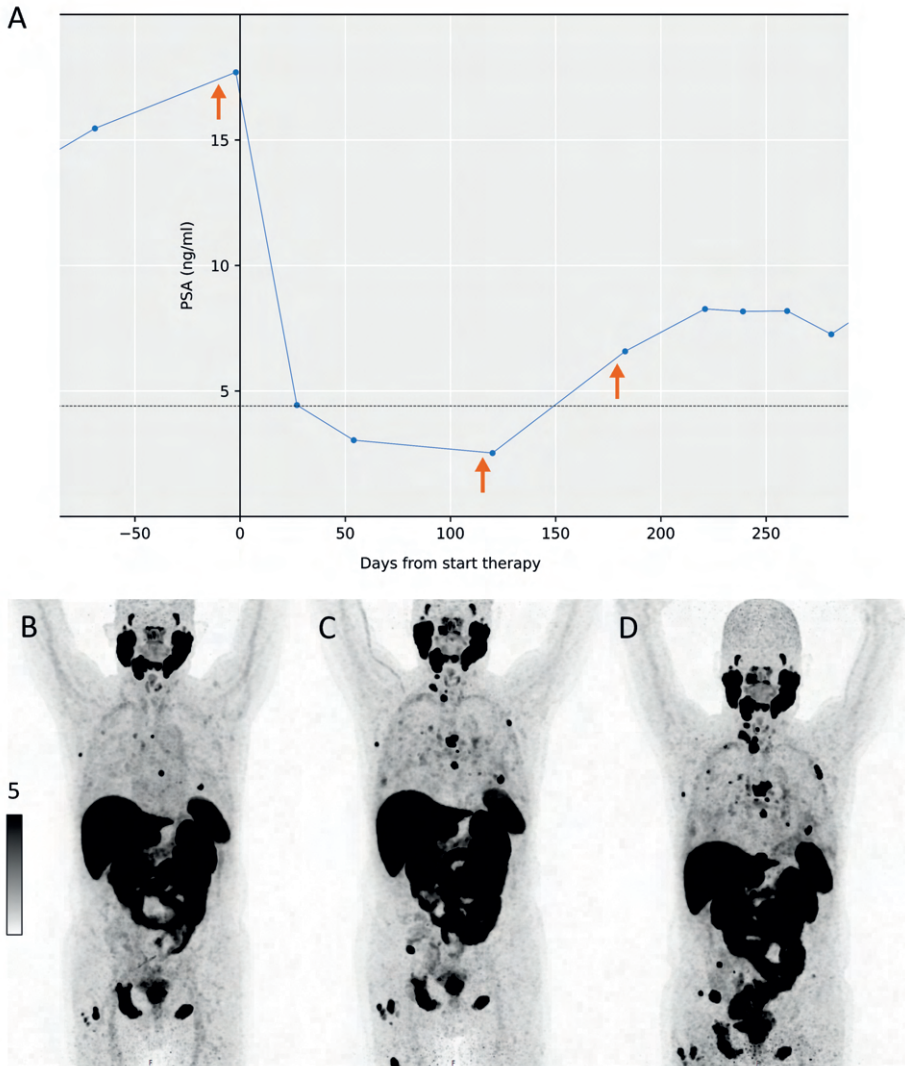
The PSA levels and [¹⁸F]PSMA-1007 PET/CT scans of a 72-year-old male with first-line enzalutamide treatment for mCRPC showed a discrepancy after four months: an 86% PSA decline, but disease progression on PSMA PET/CT with multiple new lesions. In a multidisciplinary team meeting it was decided to continue treatment as long as PSA values remained stable. After six months, treatment was stopped due to PSA progression and further progression on PSMA PET/CT. A: a graph of the patient’s PSA levels, orange arrows indicate PSMA PET/CT scan times. B: baseline PSMA PET/CT showed a PSMA-avid primary tumour and multiple bone metastases. C: PSMA PET/CT after four months of treatment demonstrated an increase in total tumour volume and tracer uptake and over 6 new lesions. D: PSMA PET/CT after six months of treatment showed a further increase in total tumour volume and tracer uptake, and over 10 new lesions.
